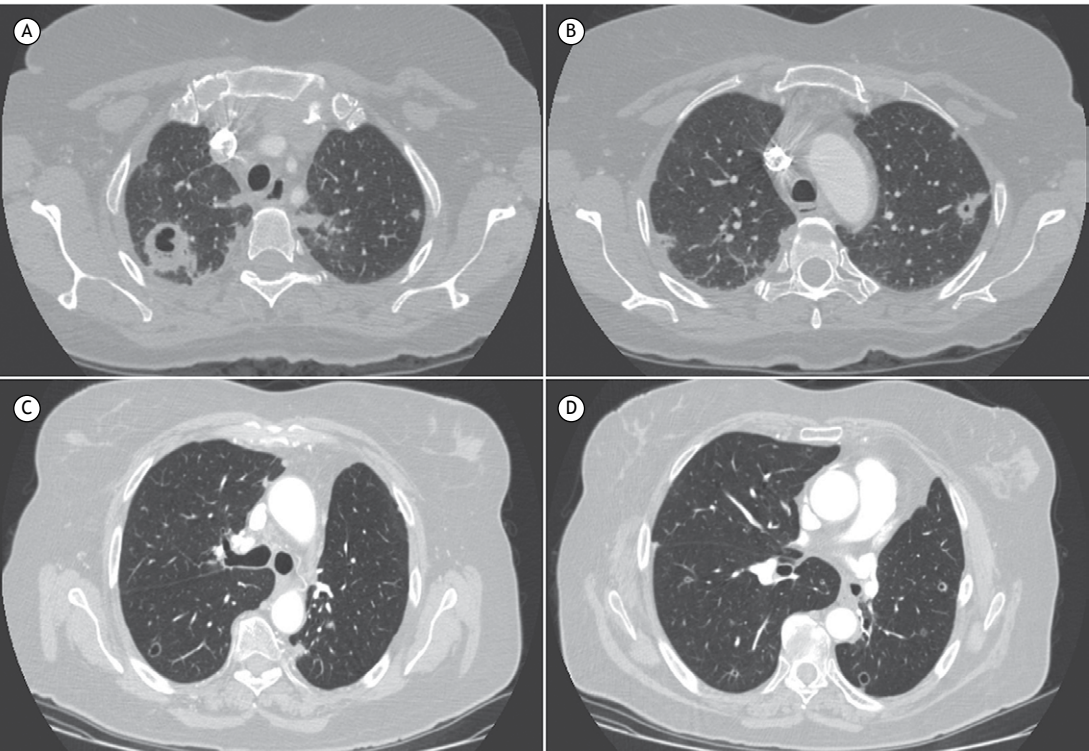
Axial CT scans of the chest of a 57-year-old female patient, showing two cavitary lesions with irregular walls and thickened upper lobes (in A and B). The final diagnosis was septic embolism. In C and D, CT scan of the chest of a 70-year-old female patient with multiple cavitary lesions, most of them thin-walled, apart from one thick-walled lesion in the lower left lobe. The final diagnosis was pulmonary metastases of a colorectal neoplasm.
